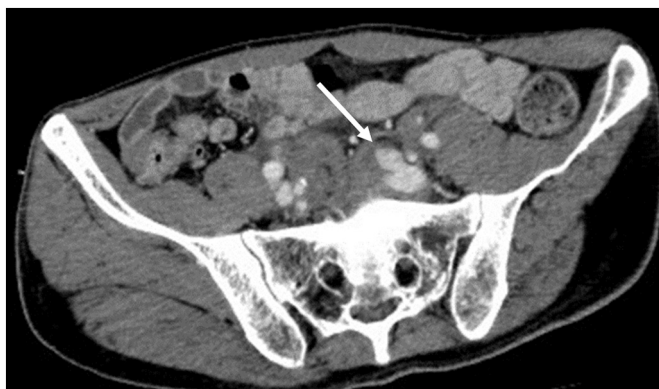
Contrast-enhanced CT shows presacral hematoma and extravasation of contrast medium in the left common iliac vein (arrow). No obvious pelvic fracture or intraabdominal organ damage is observed.
